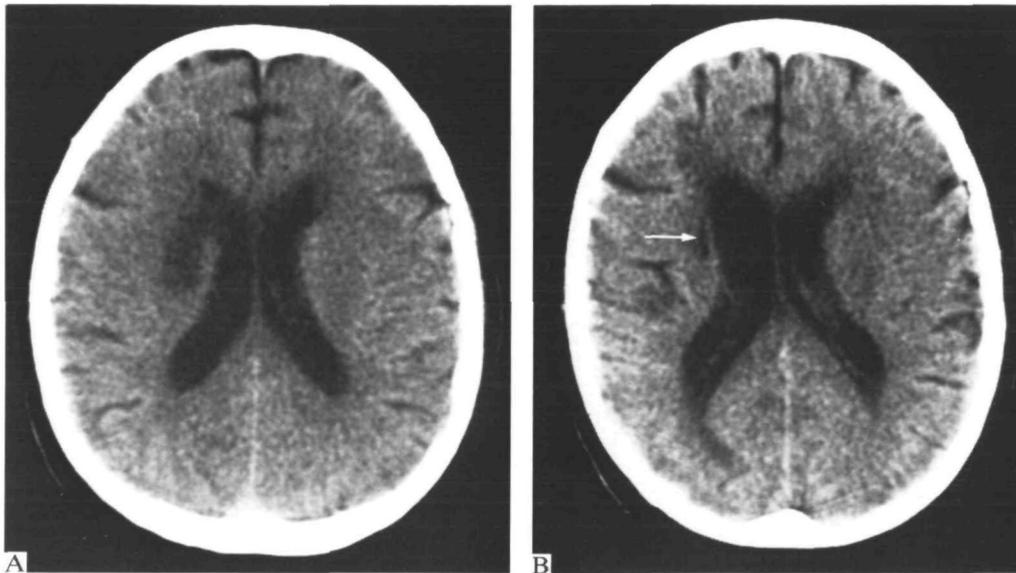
A, unenhanced CT scan showing upper portion of a right striatocapsular infarct in the paraventricular region several days after the onset of left hemiparesis. B, repeat scan 3 months later showing collapse of the infarct to a slit-like structure (arrow).
